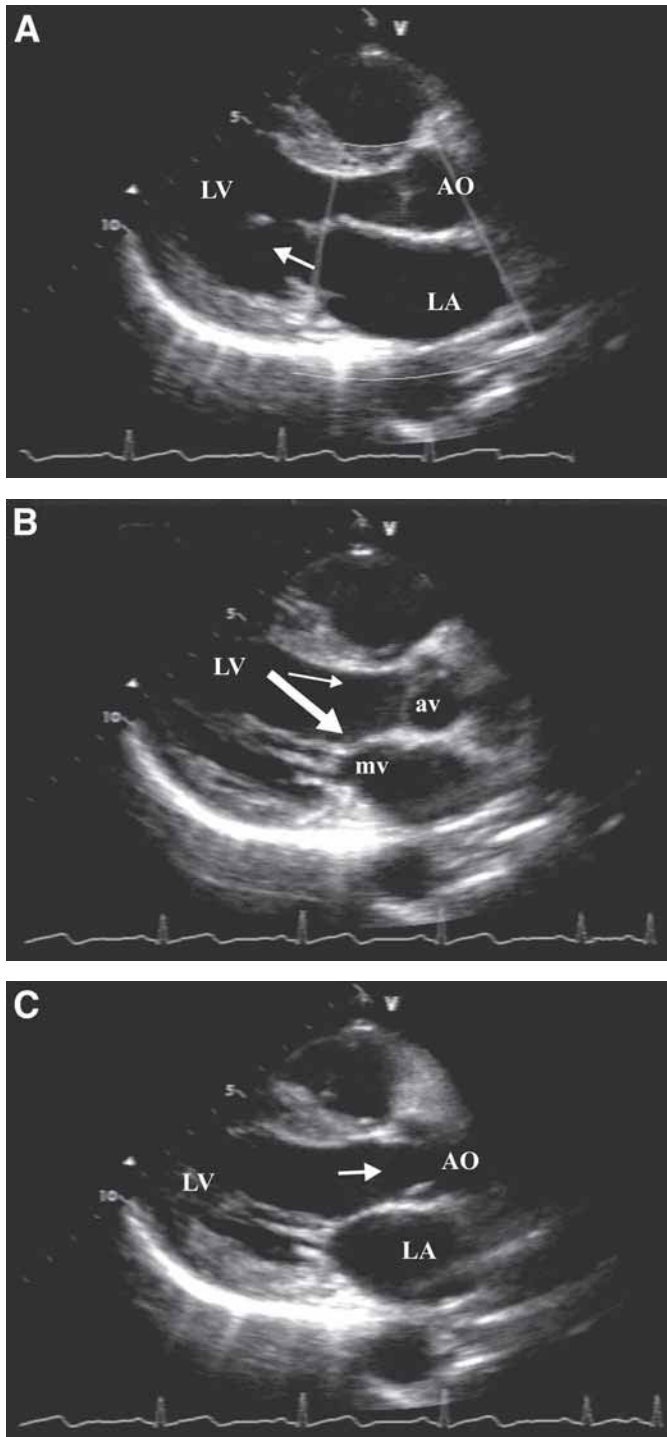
Stop frames from the two-dimensional echocardiographic recordings taken in the parasternal long axis from a normal subject showing the left ventricle (LV), mitral valve (mv), left atrium (LA), aorta (AO), and aortic valve (av) at end-diastole (A), onset systole (B), and onset ejection (C).
